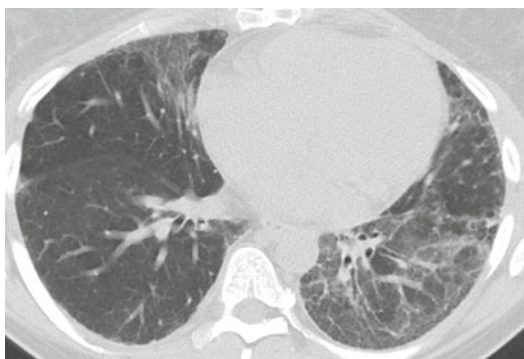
Nonspecific interstitial pneumonitis (NSIP) from topotecan. A 68-year-old man who had progressive dyspnea after receiving treatment with topotecan. CT image shows asymmetric ground glass with subtle reticulation. Bronchoalveolar lavage was unrevealing and patient underwent biopsy which was most in keeping with NSIP
